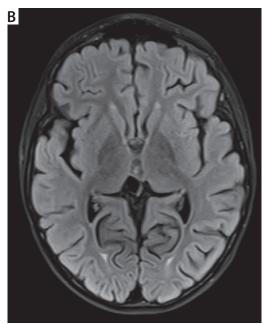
Head MRI – T1 weighing, transverse cut (A) hypertensive foci visible bilaterally in globus pallidus (SWI sequence with low signal foci – not presented); image suggestive for haemorrhage within ischaemic lesions and inflammation of the small vessels, (B) partial regression of lesions
